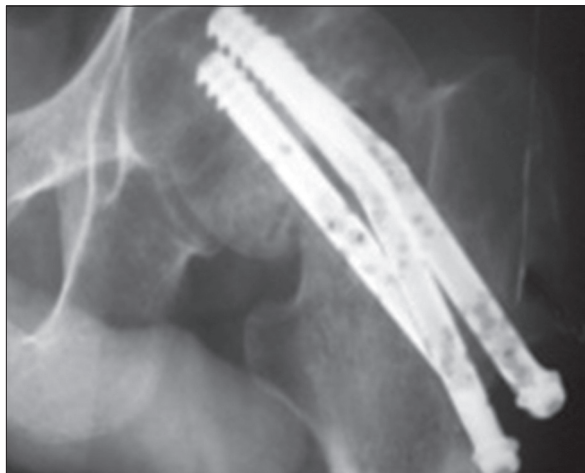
X-ray left hip joint anteroposterior view treated with BIHS showing implant breakage in the phase 2 series
